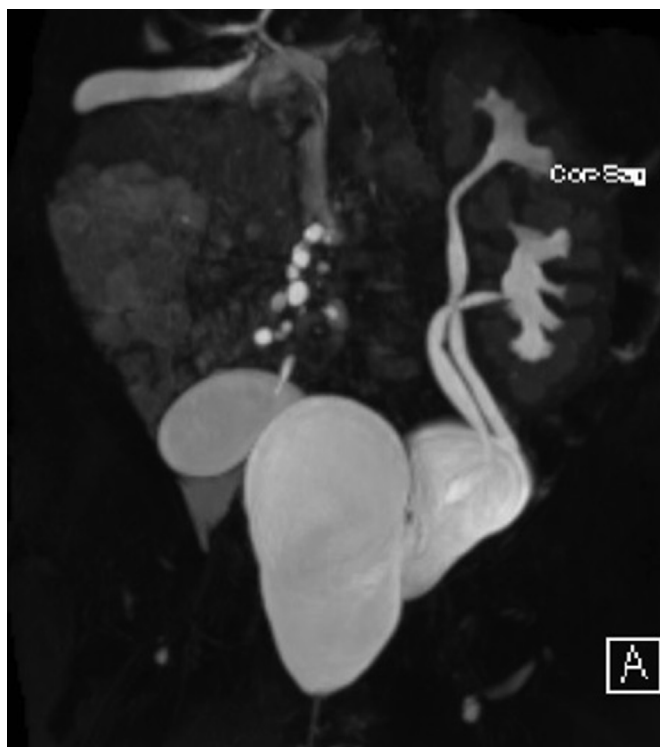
Magnetic resonance imaging (T2 phase) demonstrating a dysplastic right kidney with dilated right uterine horn and obstructed hemi-vagina as well as a left collecting system duplication.
